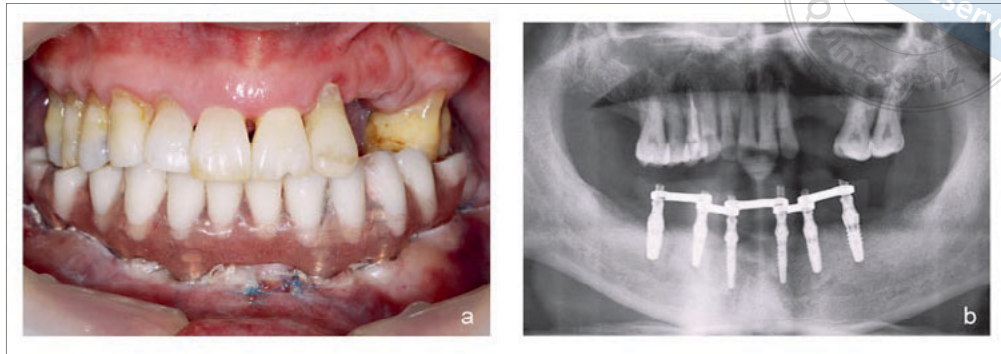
(a) Interim prosthesis in place immediately after implant surgery; (b) panoramic radiograph after immediate loading.
